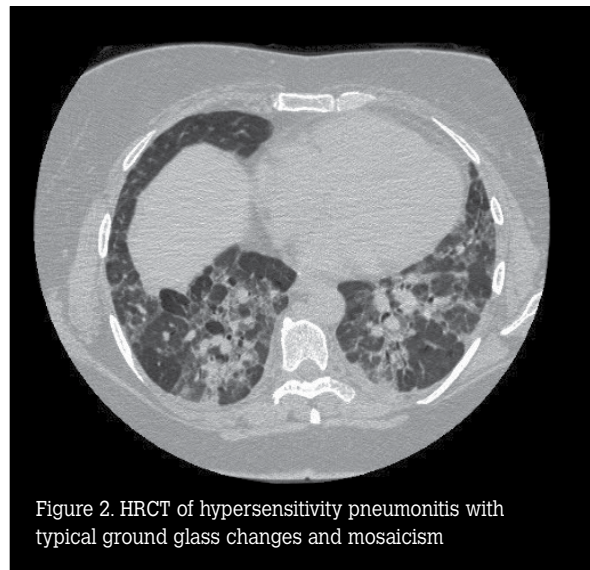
HRCT of hypersensitivity pneumonitis with typical ground glass changes and mosaic attenuation
